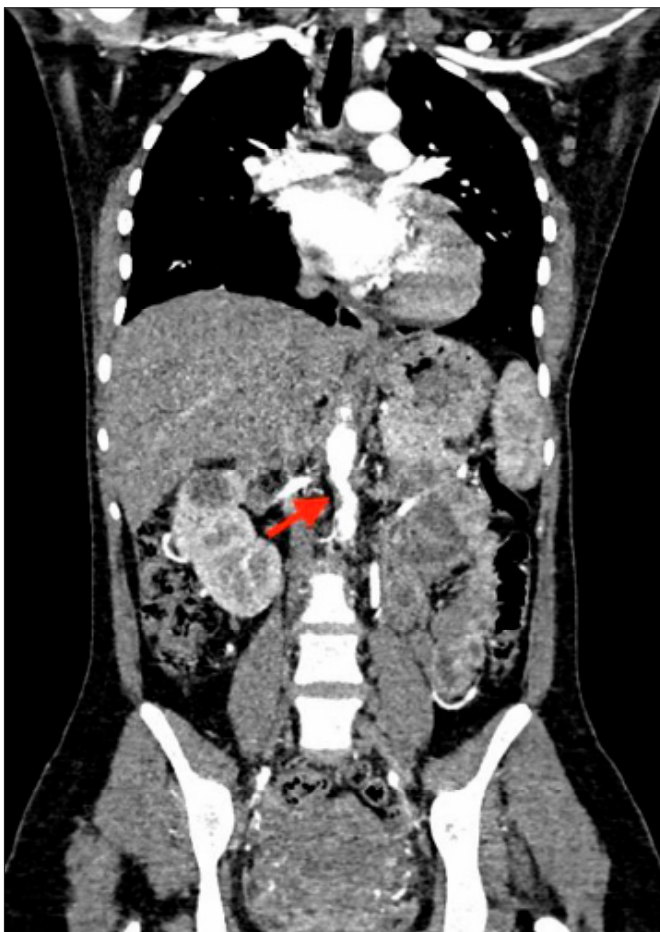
CT angiogram showing narrowing of the abdominal aorta below the level of the renal arteries
